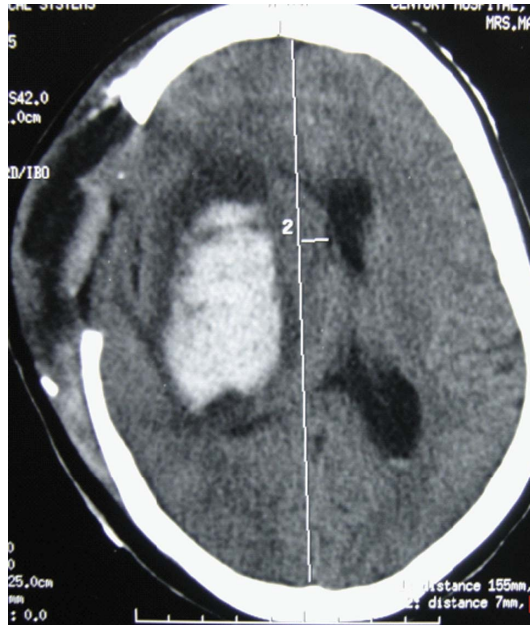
CT scan showing the hemicraniectomy and reduction in size of the hematoma.
